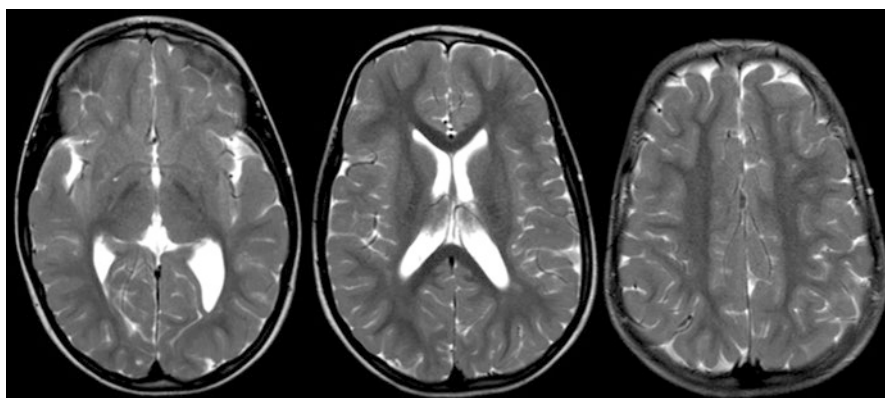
MR image at 4 years of age
